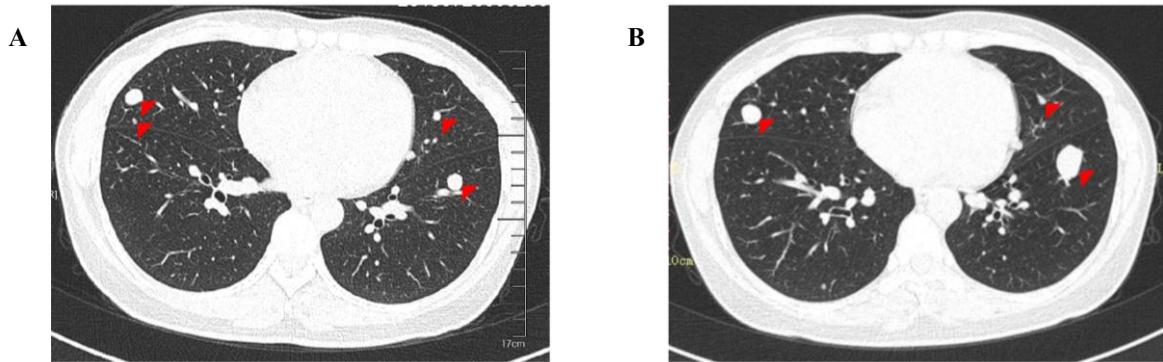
Chest CT images; (A) A CT scan image showing multiple lung nodules in July 2019; (B) A CT scan image showing that the nodules had enlarged and increased in number in November 2020
